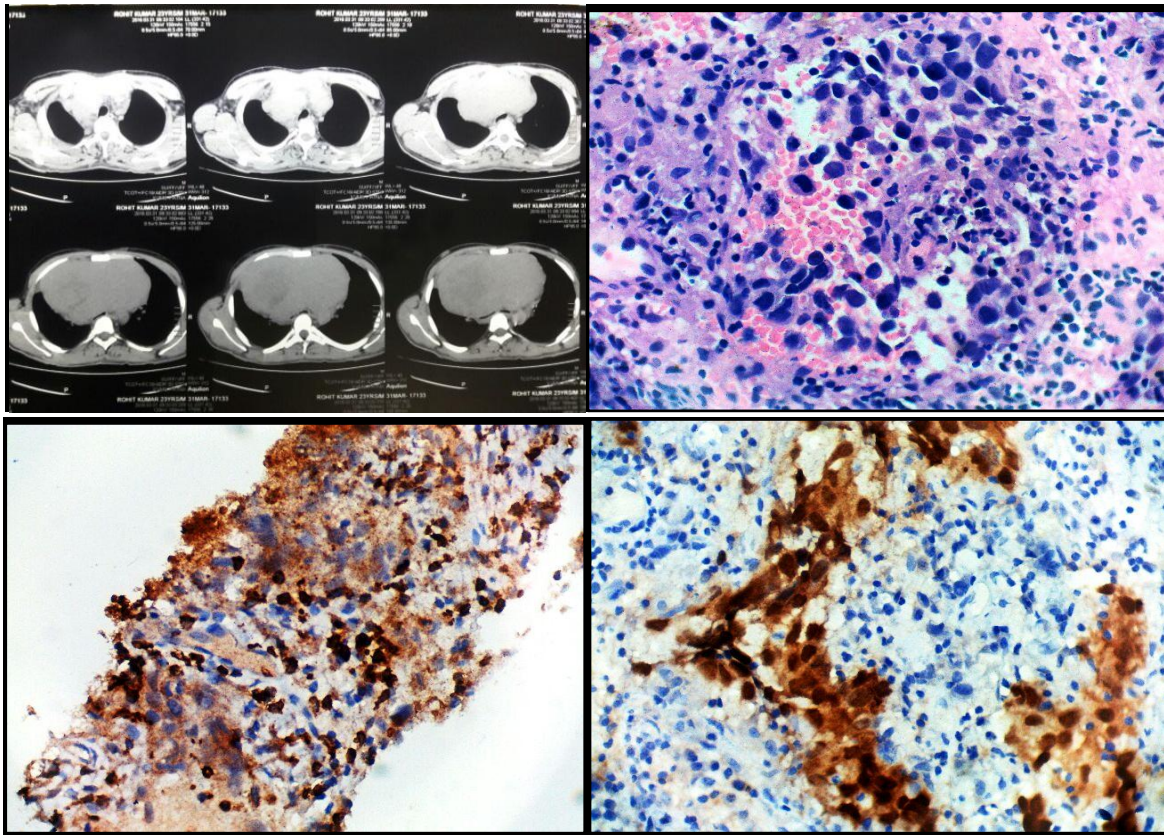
(a) CT of thoracic lesion showing mediastinal mass. 1(b) HPE from lung mass showing sheet of tumor cells with moderate amount of cytoplasm. 1(c) &1(d) IHC showing positivity of Oct ³/₄ in tumor cells and CD 5, Consistent with Germ cell tumor of mediastinum
